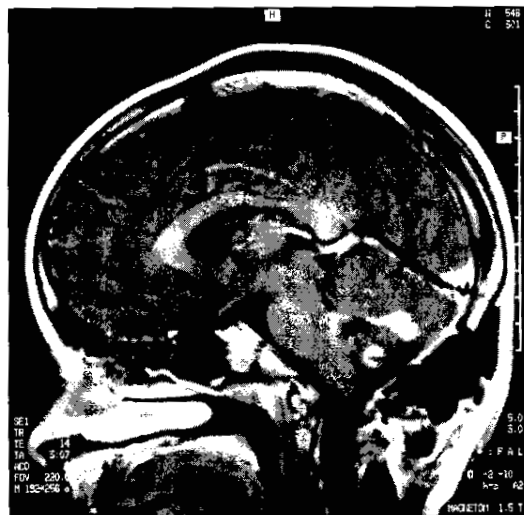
Case 4 at diagnosis: Coronal and sagittal MRI scans indicating a pontine astrocytoma arising at medullopontine angle posteriorly. Extension into fourth ventricle and involvement of middle cerebellar peduncle on right.
